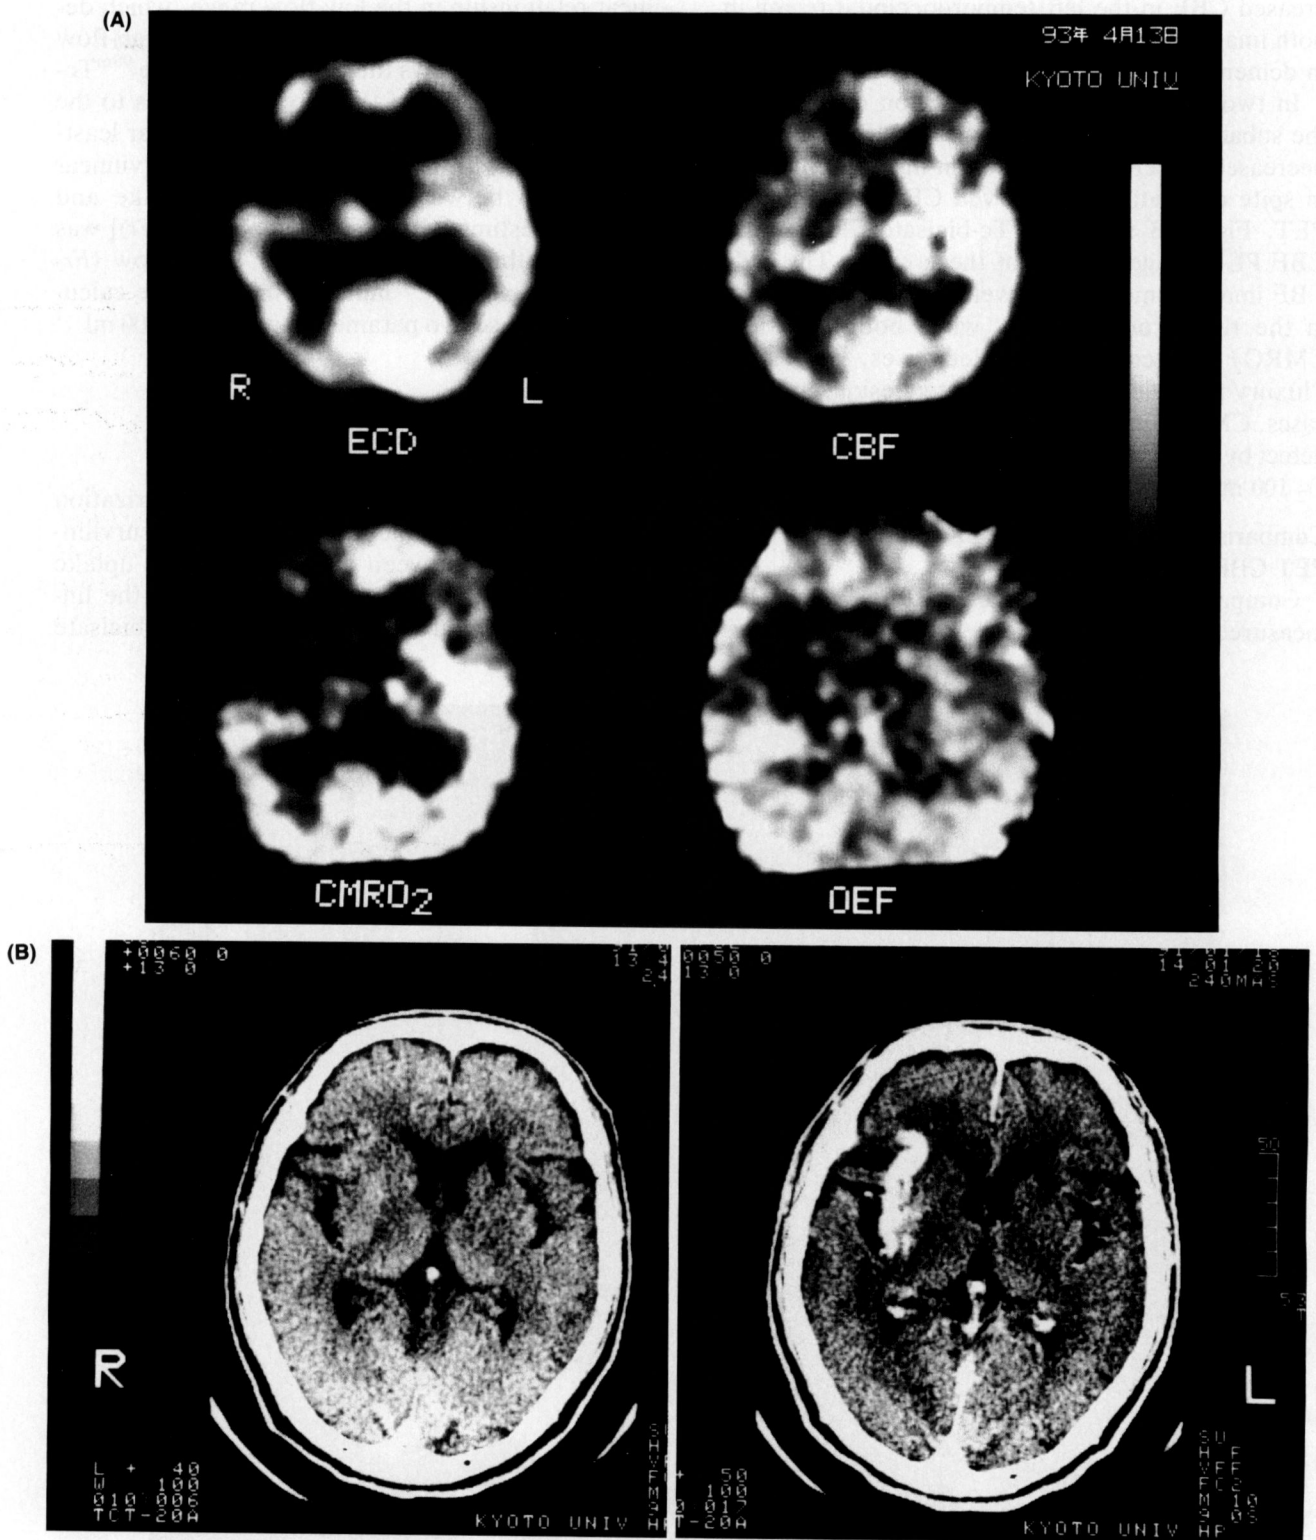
Comparison of ^{99m}Tc -bicisate (ECD) single photon emission computed tomography (SPECT) and positron emission tomography (PET) CBF images in a case with subacute cerebral infarction (19 days after onset). ^{99m}Tc -Bicisate SPECT images showed decreased uptake in the right frontal region, corresponding to the infarction demonstrated by x-ray CT. PET on the same day demonstrated relatively preserved CBF with decreased oxygen extraction fraction (OEF) and CMRO_2 , suggesting relative luxury perfusion. A: ^{99m}Tc -Bicisate SPECT and PET images; B: x-ray CT images (left: plain CT; right: contrast-enhanced CT).
